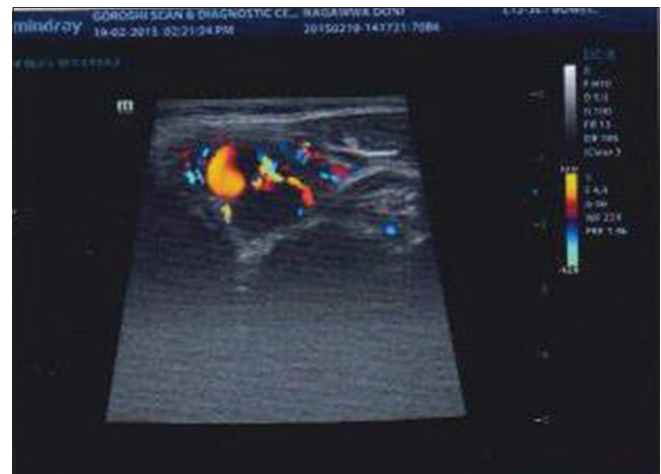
Ultrasonography showing a highly well-defined solid mass present situated near left carotid artery
